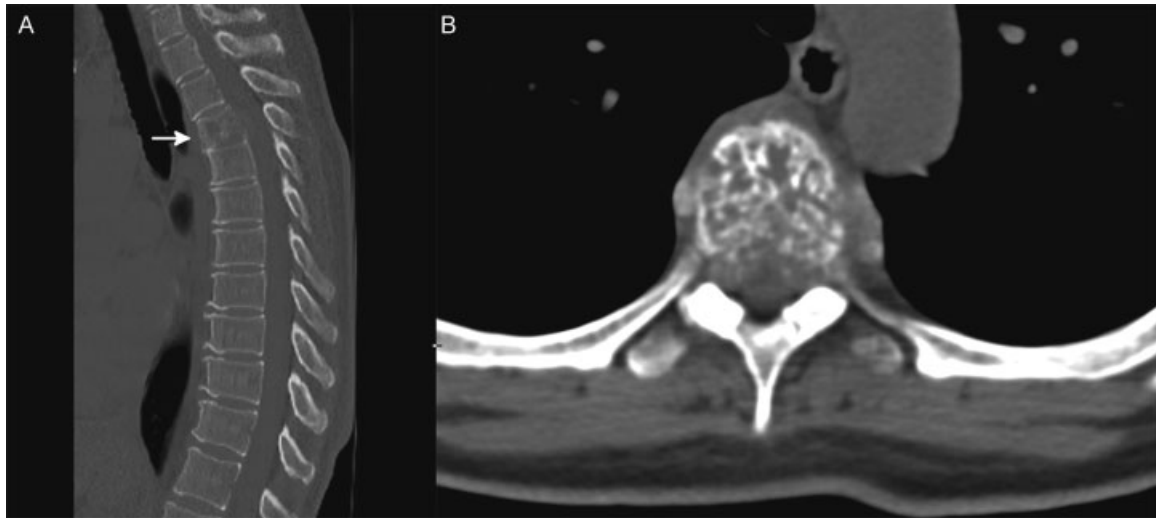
Preoperative images depicting the original hemangioma. (A) Sagittal computed tomography (CT) demonstrating the hemangioma in the T4 vertebral body (arrow). (B) Axial CT at the T4 vertebral level.
